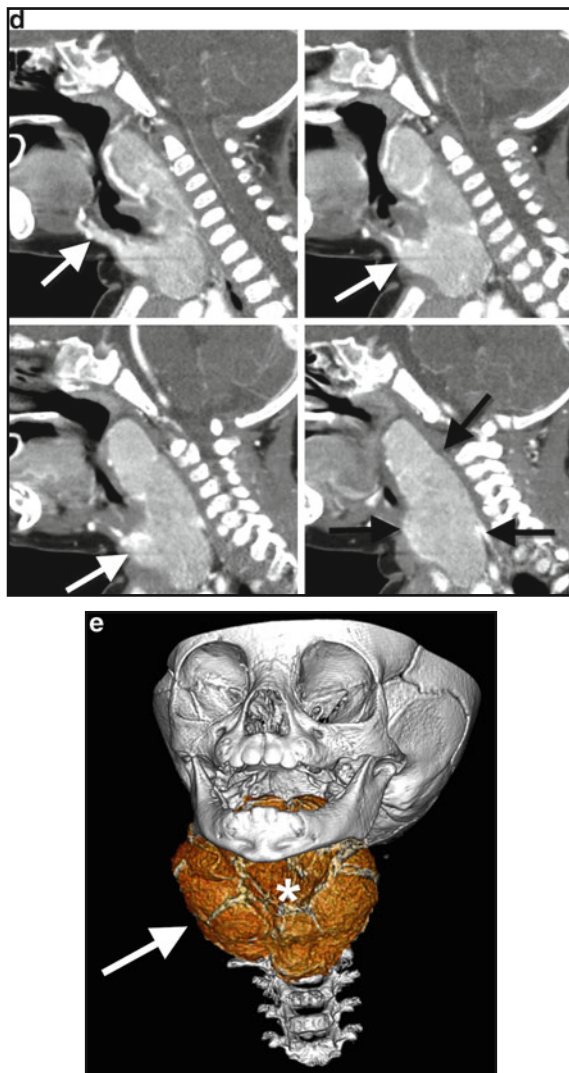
(continued) compared to the size of most high-frequency transducers and because of the relatively high positioning of the thyroid gland in the neck compared to adults. This is best appreciated on sagittal CT images from the same patient, which well demonstrates the patient's short neck and how the path of least resistance for the thyroid to enlarge is posterior (*arrows, d*). On a 3D CT reconstruction (*e*), note how the thyroid gland (*arrow*) wraps around the airway (*asterisk*).
